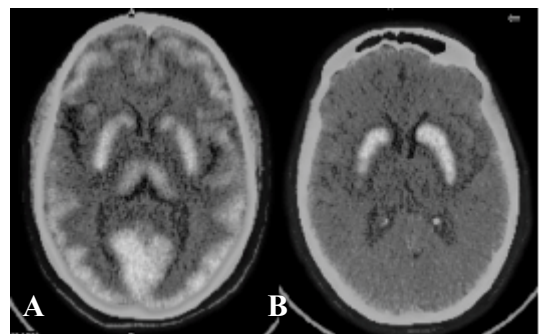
FDG-PET/CT scan in a patient with Parkinson's disease (A). Note the relative hypermetabolism in the basal ganglia compared to the metabolic activity in cerebral cortices. The F-DOPA scan (B) in this patient shows reduced uptake in bilateral putamen with preserved uptake in the cerebral cortices.
